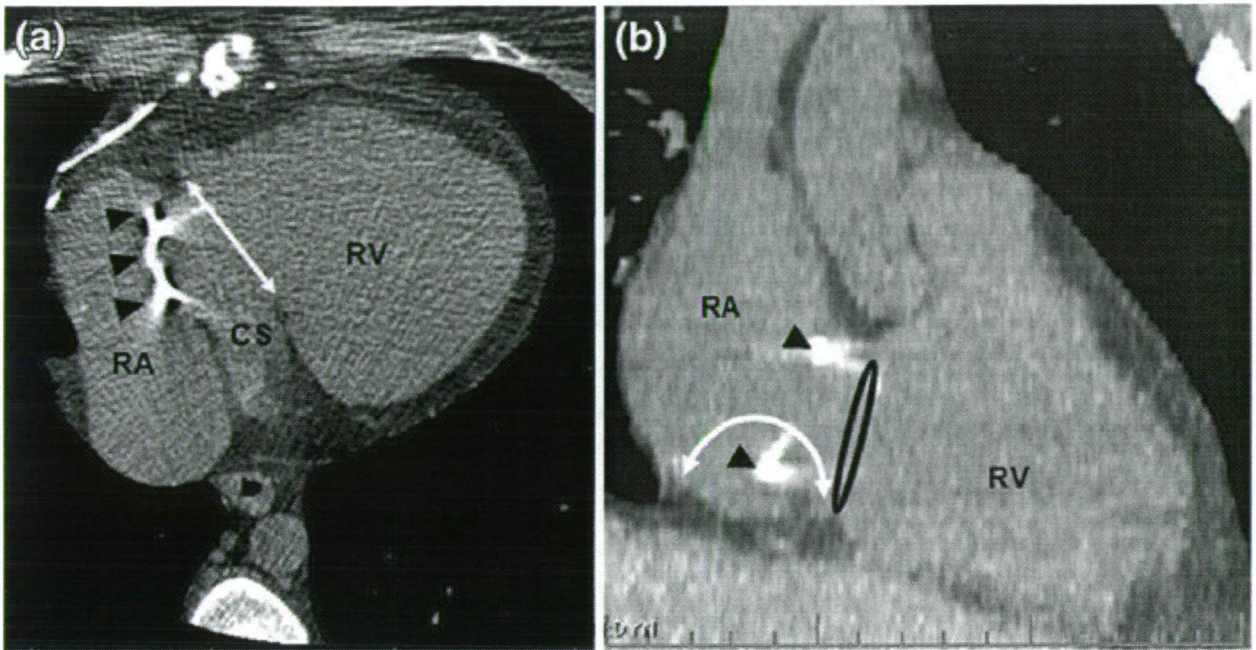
(Panel a). 16 slice contrast-enhanced spiral CT image showing the CS draining into the RV under the ring of the artificial valve (arrowheads). The double arrow shows the location of the native tricuspid annulus. (Panel b). Reconstructed CT image corresponding to right anterior oblique fluoroscopic projection. The CTI is marked by the double arrow.
